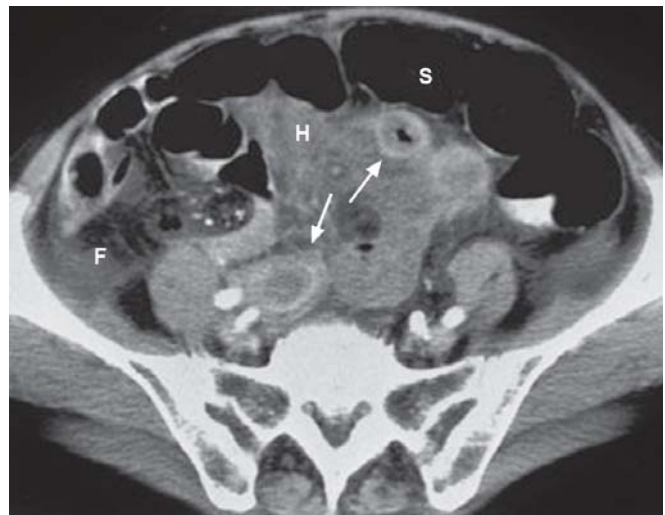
CT scan abdomen
